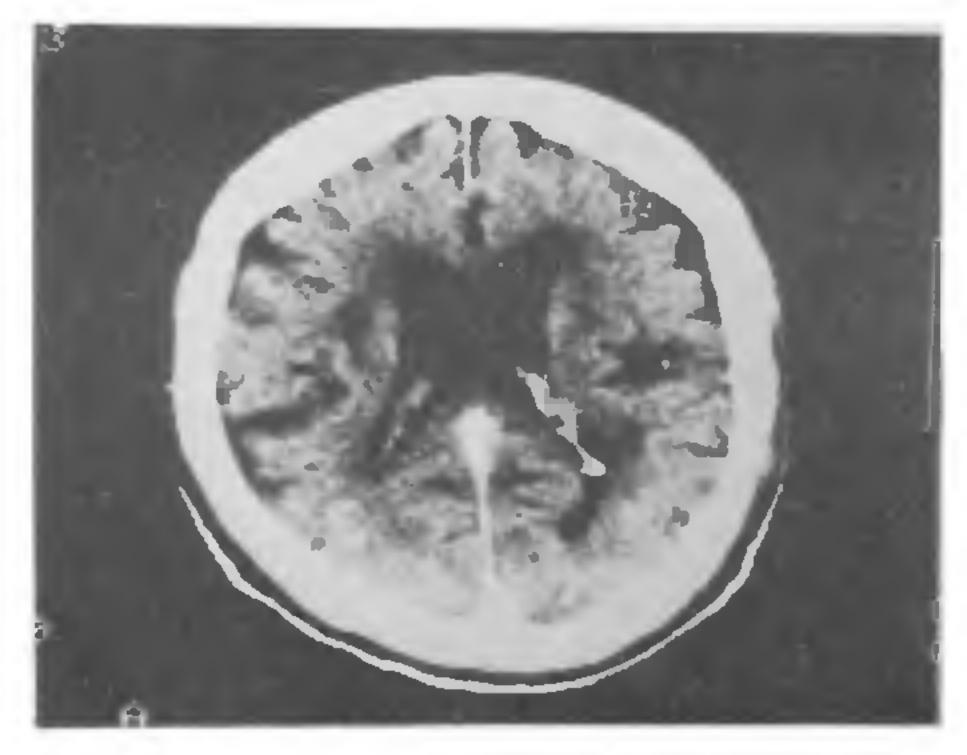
Axial brain CT scan of a man aged 70 years, showing bilateral periventricular deep white matter, low attenuation areas (infarcts) with mild dilatation of lateral ventricles and prominent cortical sulci.
